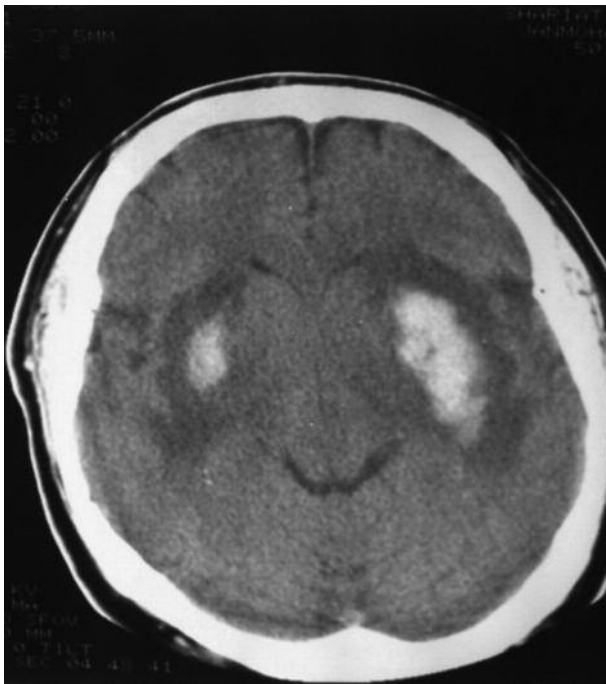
Brain CT scan without contrast in first hours after his sudden attack of unconsciousness, shows bilateral basal ganglia hemorrhagic necrosis.
